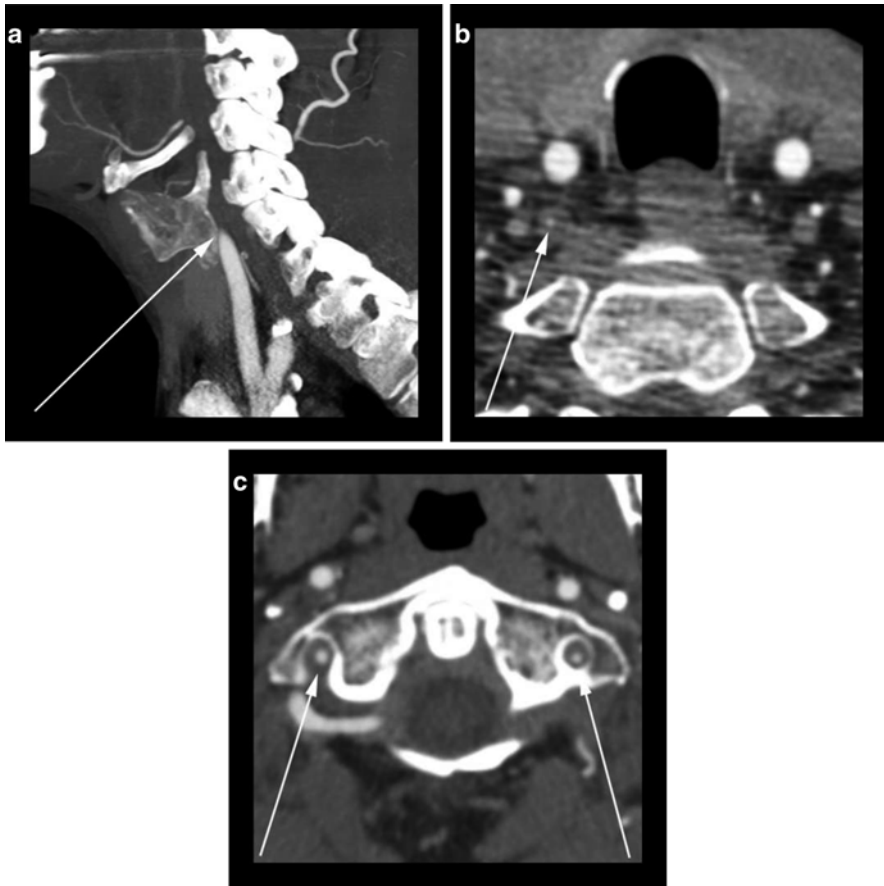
50-year-old male presenting with dizziness and vertigo. (a) Sagittal CTA MIP suggests complete proximal occlusion (arrow) of the right vertebral artery related to mixed density atherosclerotic plaque. (b) An axial CTA image shows a string of contrast opacification (arrow) within the vertebral artery lumen suggesting the MIP reconstruction overestimated the degree of stenosis. (c) An axial CTA image at the level of the C1 vertebral body shows bilateral V2 and V3 segment vertebral artery opacification (arrows); although, it cannot be ascertained on this single phase CTA examination whether flow within the vertebral arteries is antegrade or retrograde
